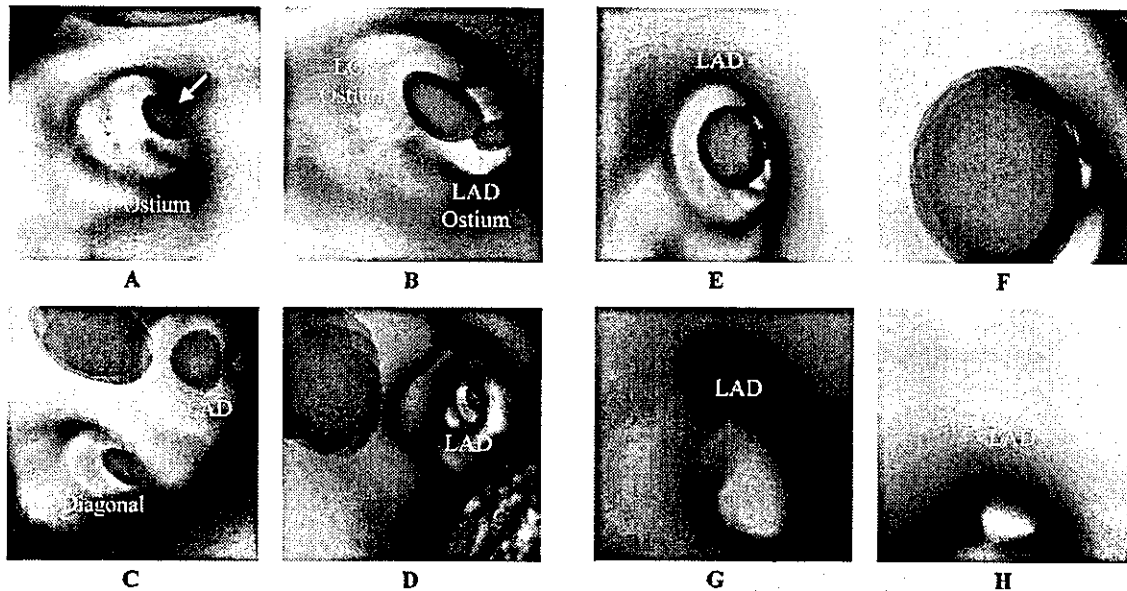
Endoluminal perspective volume renderings of the coronary arteries using electron-beam computed tomography (EBCT) show the inside of the lumen of the coronary arteries. The shapes of the opacity curves and color curves were the same as in Fig 3D. Calcified plaque with CT numbers well above those of the contrast-enhanced coronary artery lumen could be distinguished by perspective volume rendering. (A) The left main (LM) ostium is shown. Calcified plaque as represented in red is inside the LM (arrow). (B) Bifurcation of the left anterior descending coronary artery (LAD) and the left circumflex branch (LCx) is shown. Calcified plaque in the bifurcation of the LAD artery and LCx and LAD ostium can be noted. (C) Bifurcation of the LAD and the first diagonal branch (1st Diagonal) is shown. (D) The lumen of the LAD is shown. The right lower part of the vessel wall was eliminated by an inappropriate setting of the opacity curves artificially. (E,F) The lumen of the distal part of the LAD is evident. There was a huge mass of calcified plaque (arrow) and that site was approximately equal to the corresponding site of stenosis as revealed by conventional coronary angiograms. (G,H) The lumen of the further distal part of the LAD is shown. Calcified plaque was not observed, possibly because of the limits of capability of the spatial resolution of the EBCT scanner and partial volume effects.
